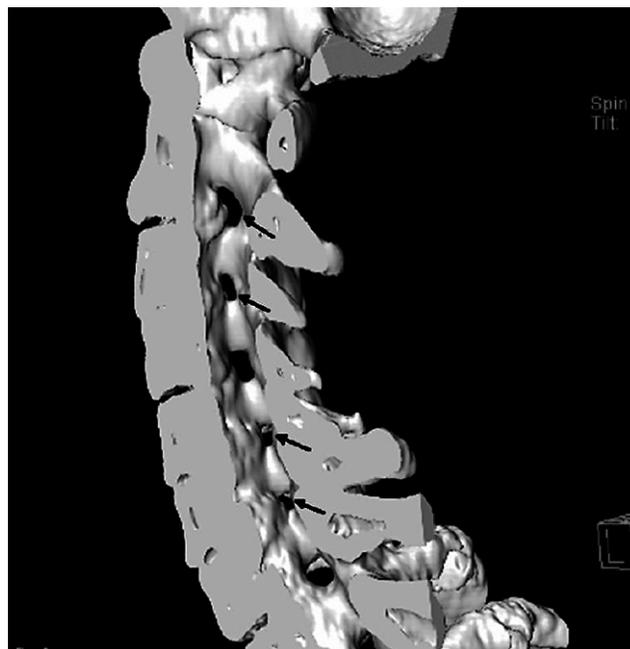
Three-dimension computed tomography intercanal reconstruction of bony structures of the cervical spine. Black arrows indicate narrowing of the intervertebral foramens
